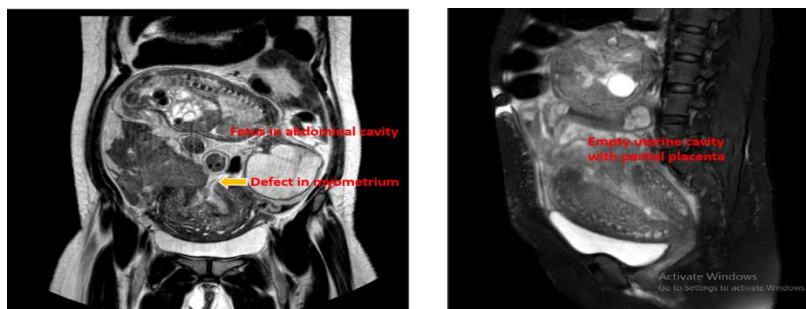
MRI showing posterior wall rupture of uterus with fetus in the abdominal cavity. The second image shows partial attachment of placenta to fundus with empty uterine cavity
